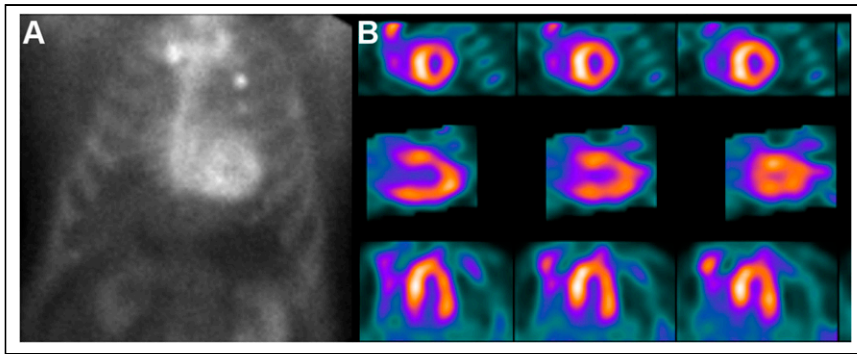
Abnormal planar and SPECT ^{99m}Tc -pyrophosphate cardiac amyloidosis scans. (A) ^{99m}Tc -pyrophosphate planar anterior image showing avid myocardial uptake. (B) SPECT short-axis (top), vertical long-axis (middle), and horizontal long-axis (bottom) images of same patient showing diffuse myocardial uptake. This scan is considered diagnostic of ATTR cardiomyopathy if serum and urine studies for AL are negative. (Reprinted from (2).)
